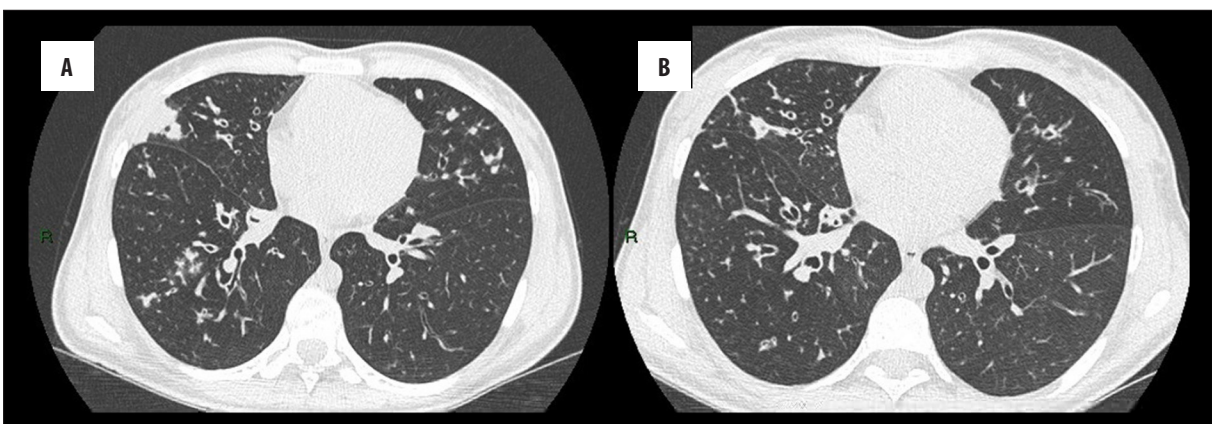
HRCT. Axial image A presents bronchiectasis with peribronchial thickening. Some of the bronchi are filled with mucus. Additionally, image (A) depicts inflammatory subsegmental and peribronchial consolidations. Follow-up HRCT image in picture (B) reveals partial resorption of the inflammatory consolidations and mucus plugs.
